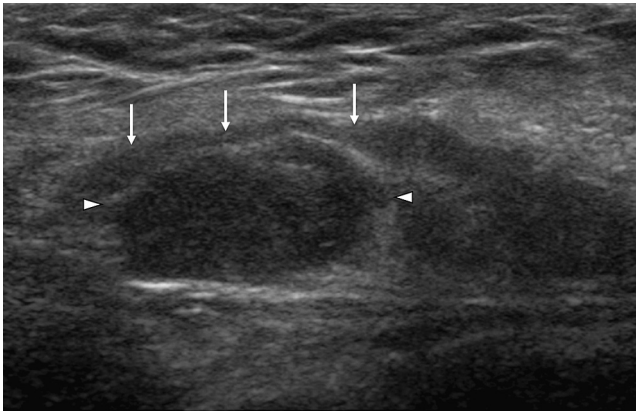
An undescended testis in the inguinal canal. A longitudinal sonogram of the groin region, showing an oval-shaped hypoechoic structure (white arrowheads) within the inguinal canal consistent with an undescended testis. The testis is slightly smaller than the normal testis (not shown) due to expected atrophy. There was only a single testis in the scrotum. Epididymis and spermatic cord (white arrows).
